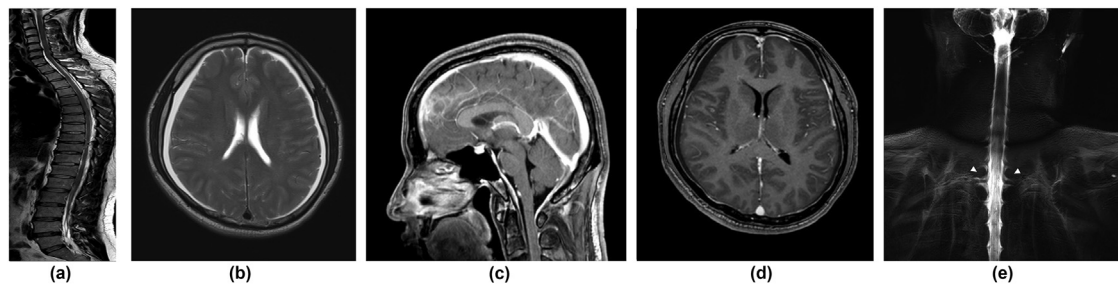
Representative case of a 45-year-old man with orthostatic headache, nausea, vomiting, dizziness, and tinnitus. (a) Sagittal spine MRI image showing epidural fluid collection within the ventral aspect of the spinal canal at cervicothoracic junction and the dorsal aspect of the spinal canal at thoracic level. (b) Axial T2-weighted brain MRI image showing bilateral subdural fluid collection. (c) Sagittal enhanced T1-weighted image showing venous engorgement, enlarged pituitary gland, and brain sagging. (d) Axial enhanced T1-weighted image showing diffuse pachymeningeal enhancement. (e) Maximum intensity projection 2D MR myelography images showing CSF leakage at cervicothoracic junction (arrowheads).
